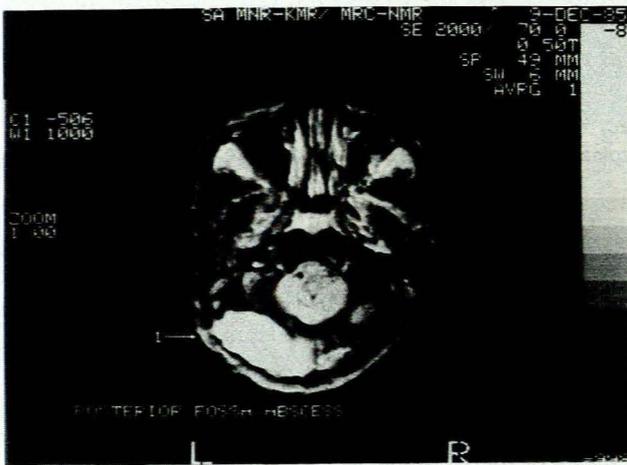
MRI of the posterior fossa of the same patient in the transaxial plane clearly showing a large posterior fossa abscess (SE 2000/70).
